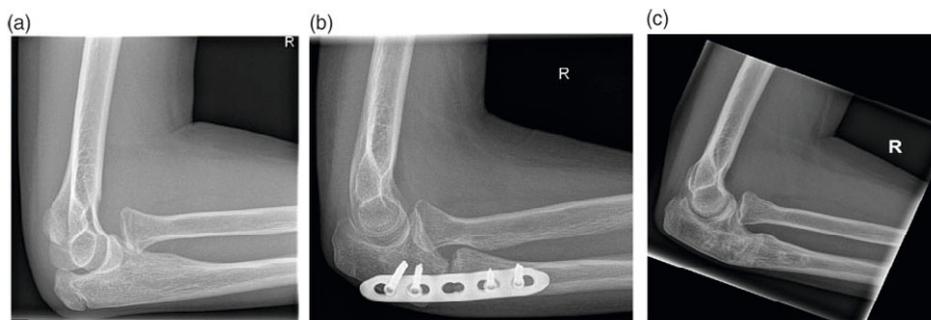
(a). Preoperative X-ray of the elbow in a patient that had sustained a Monteggia injury two years earlier; (b) X-ray of the elbow six weeks after ulna osteotomy and annular ligament reconstruction; (c) outcome 1.5 years after surgery.
